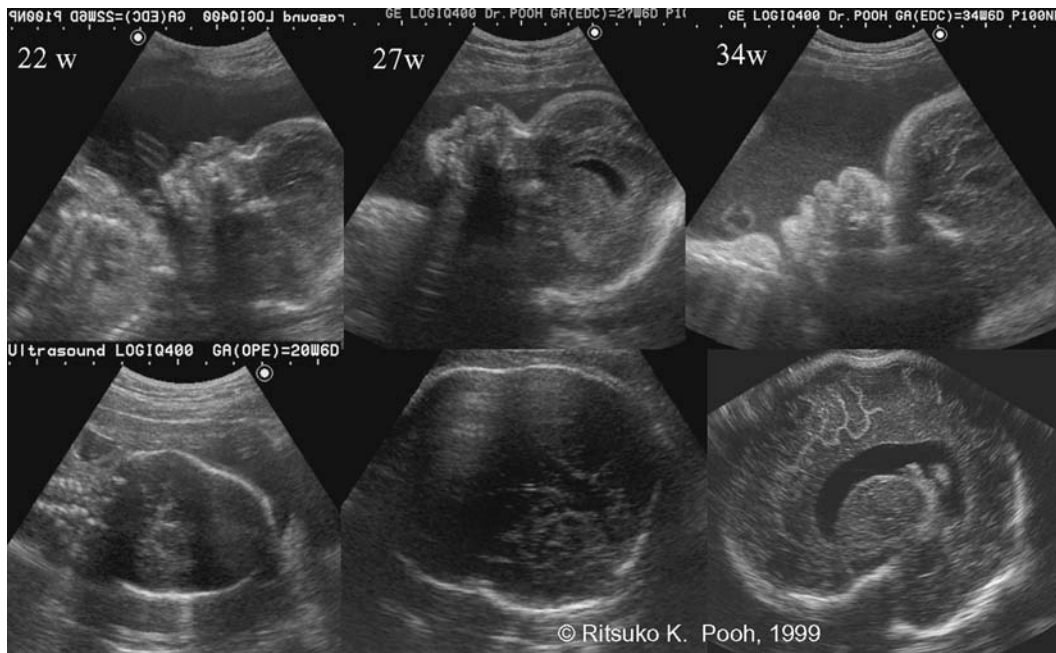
Prenatal craniofacial appearance of Apert syndrome. (Upper) Longitudinal changing appearance of frontal bossing and low nasal bridge at 22, 27, and 34 weeks of gestation in a case of Apert syndrome. (Lower left) Irregular cranial shape at 20 weeks. (Lower middle) Cranial shape at 34 weeks. Note the bilateral indentation. (Lower right) Intracranial sagittal ultrasound image at 34 weeks. Mild ventriculomegaly is seen.
